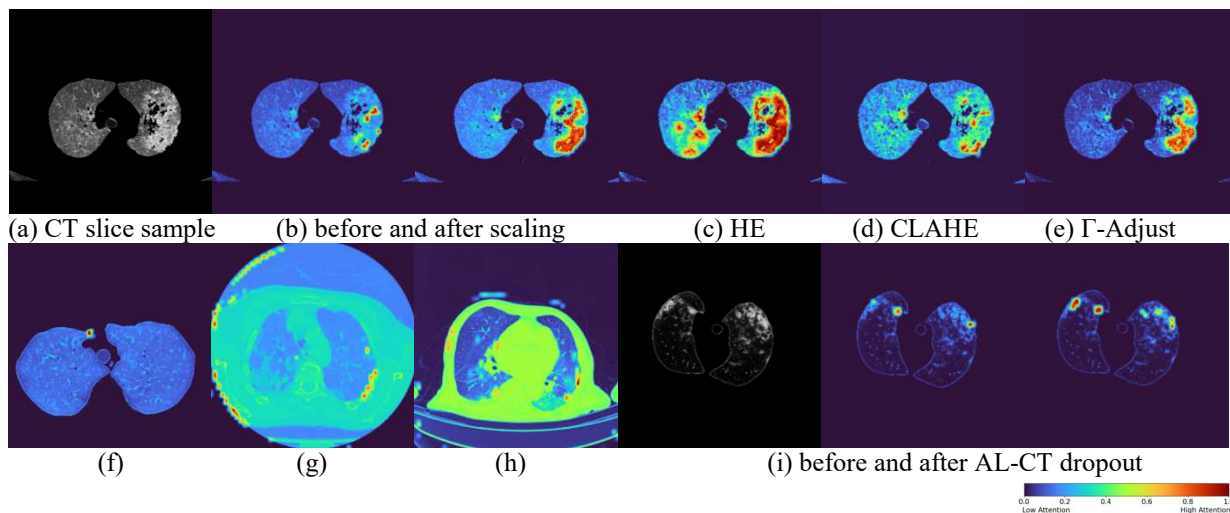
(a) a COVID-19 infected CT slice, (b) GradCAM before and after global datasets scaling, (c) – (e) GradCAM of the models trained from datasets enhanced with global histogram equalization, CLAHE and supervised gamma adjustment, (f) low attention GradCAM response of a health lung, (g) – (h) GradCAM of unsegmented COVID-19 and CAP, (i) a COVID-19 CT slice and GradCAM before and after the proposed AL-CT dropout.
